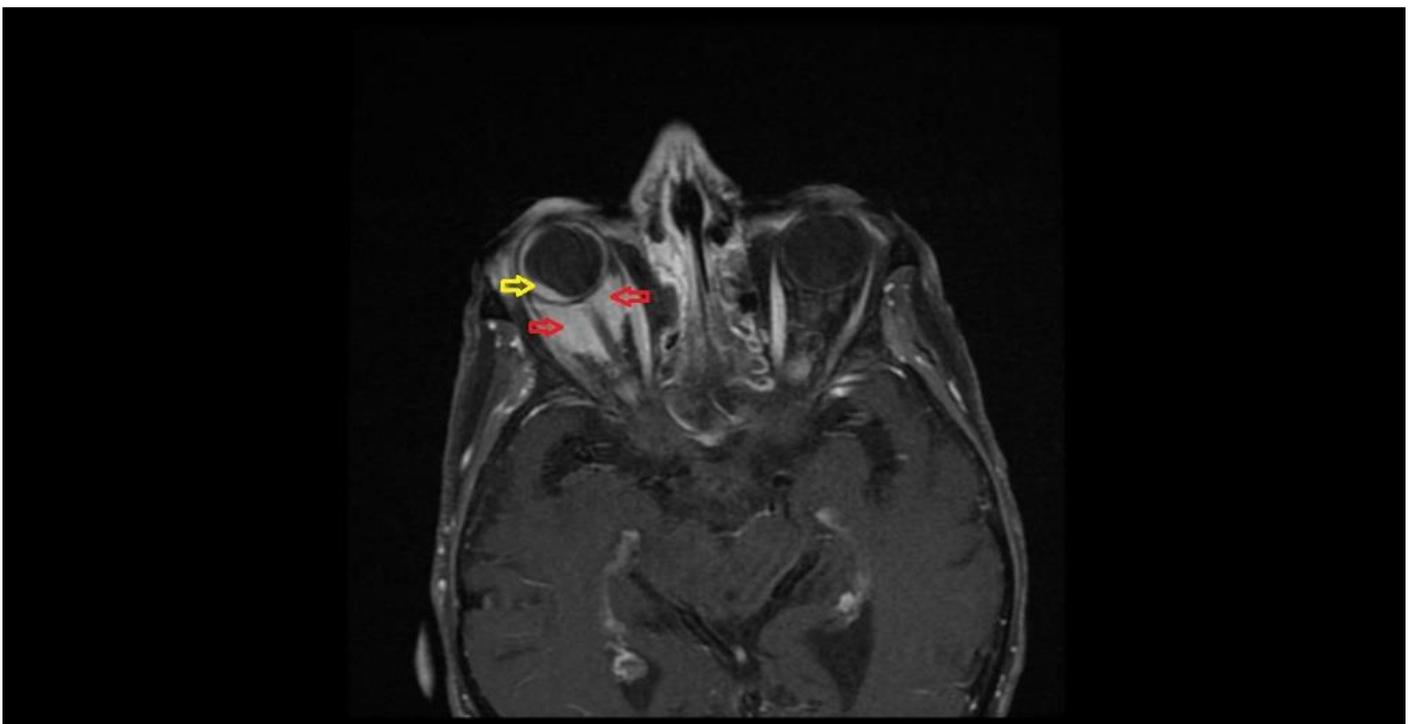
The axial T1-weighted fat suppressed with gadolinium contrast MRI scan of optic nerve sheath meningioma (red arrow) and globe invasion (yellow arrow)
